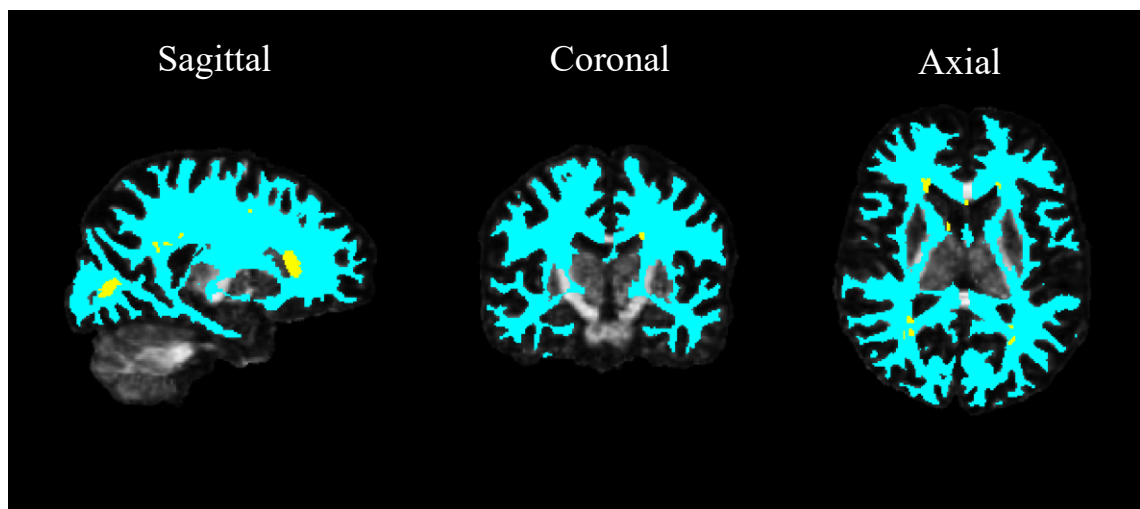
NAWM mask (blue) with excluded T2 lesions (yellow) overlapped with T1-weighted image (slice coordinates $X = 77$, $Y = 109$, $Z = 77$).
